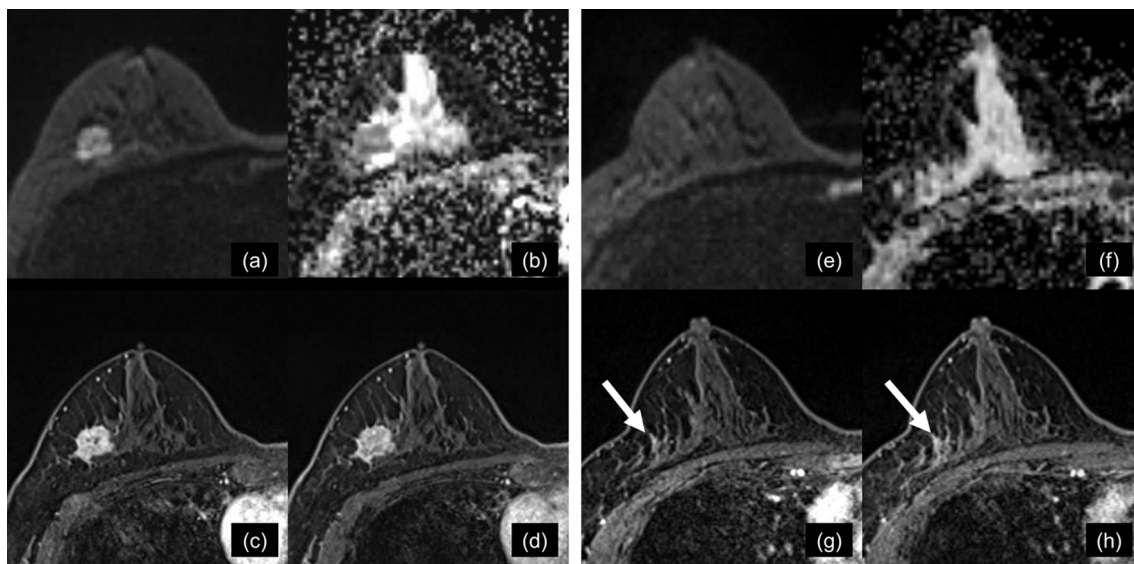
(a) Pre-NST DWI. (b) Pre-NST ADC map. (c) Pre-NST DCE-MRI early phase. (d) Pre-NST DCE-MRI delay phase. (e) Post-NST DWI. (f) Post-NST ADC map. (g) Post-NST DCE-MRI early phase. (h) Post-NST DCE-MRI delay phase. Right triple-negative breast cancer in a 64-year-old patient who underwent NST for invasive carcinoma. Pre-NST MRI showed a 22-mm mass on DWI and DCE-MRI. After treatment, no high signal intensity remained on DWI; focal enhancement with persistent kinetics was observed on DCE-MRI (g, h, arrow). The DWI score was 0 and the kinetic score was 1. The patient underwent surgery and had no residual disease. Both the DWI score and the kinetic score suggested a correct diagnosis.
